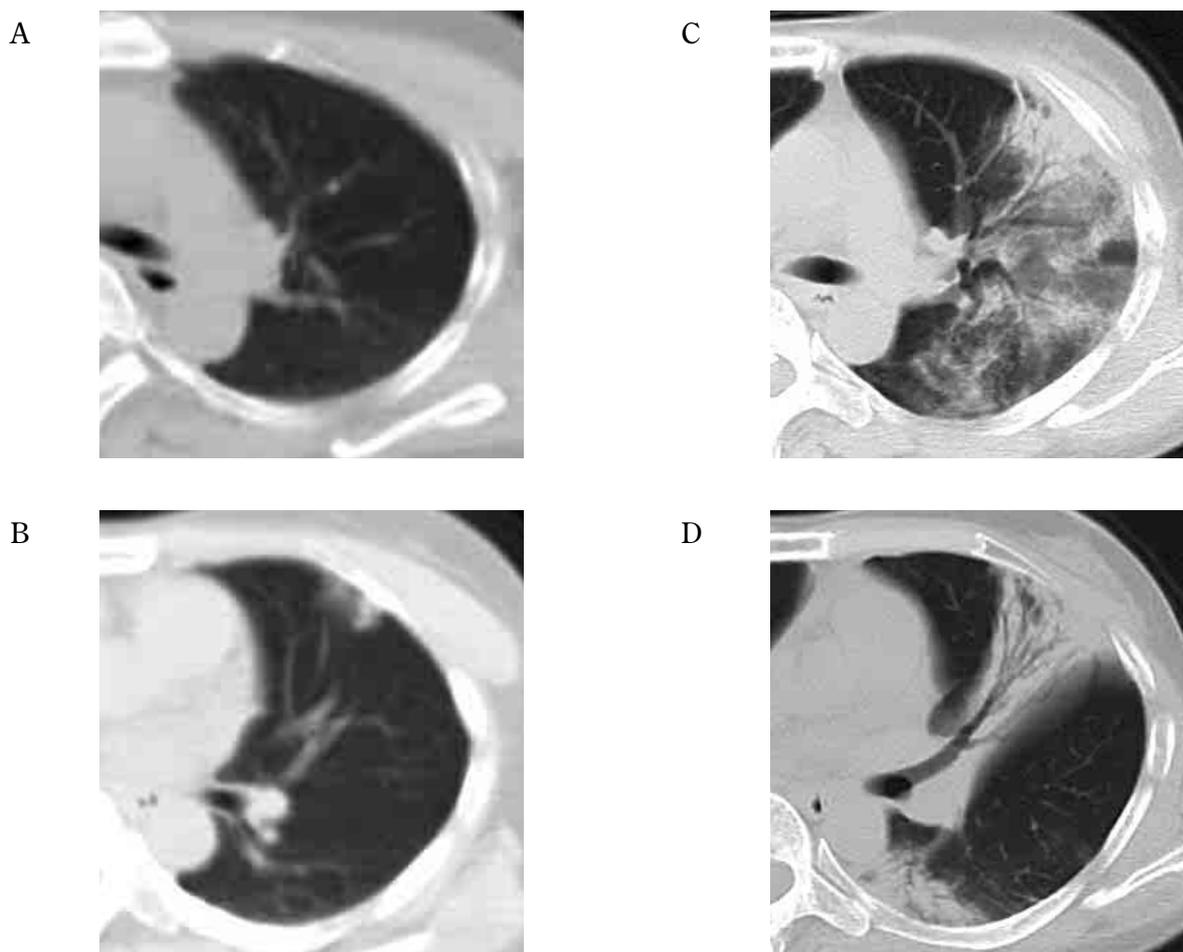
A 39-year-old woman had been continuously taking immunosuppressive agents for the treatment of chronic rheumatoid arthritis. No abnormalities were recognized from the treatment planning CT before irradiation or from the chest radiograph taken 3 months after irradiation. Partial suspension of immunosuppressive agent administration 20 months after irradiation led to the detection of a localized concentration increasing region by chest CT conducted 22 months after irradiation. No symptoms were indicated at this point. Chest CT conducted 23 months after irradiation, however, revealed a clinical symptom consisting of infiltrative shadows and ground-glass opacity expanding outside the radiation field. They were diagnosed as organized pneumonia by bronchoscopy (A, B : CT performed 20 months after irradiation, C, D : CT performed 23 months after irradiation).
